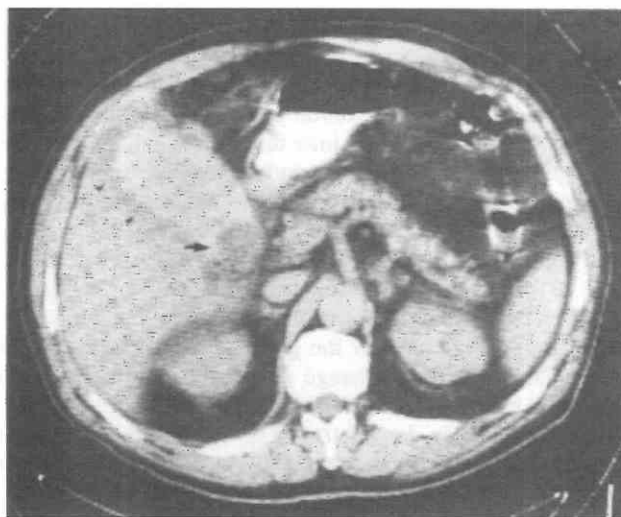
Hemorrhagic cholecystitis. The gallbladder wall is thickened (arrowheads), and its intraluminal contents are abnormally increased in density, representing blood mixed with bile. The rounded area of decreased density within the neck of the gallbladder (arrow), is a calculus. (From Jenkins M, Golding RH, Cooperberg PL: Am J Roentgenol 140:1197-1198, © by American Roentgen Ray Society, 1983.)
